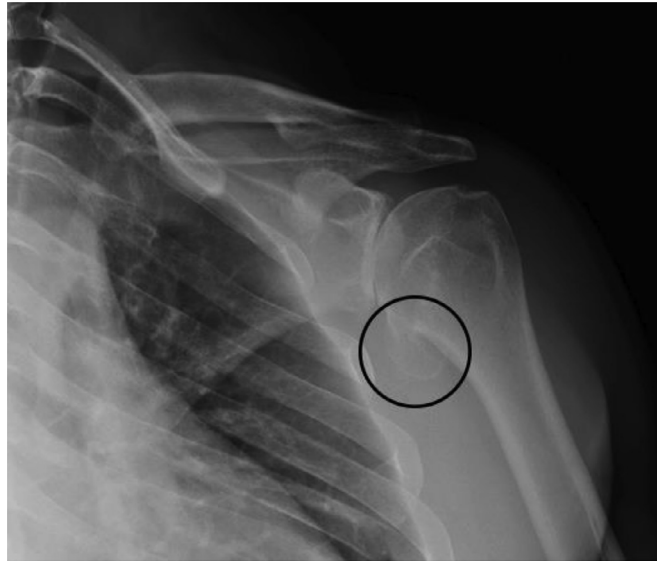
A Grashey view of the left shoulder radiograph demonstrates a large inferior osteophyte (black circle).
